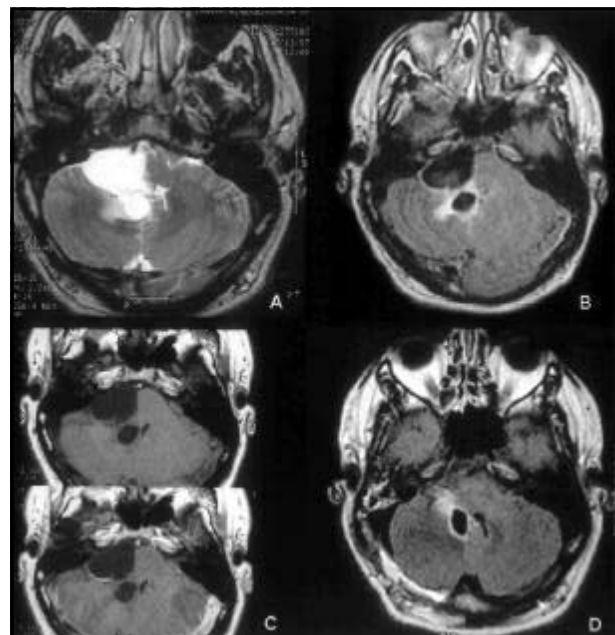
MRI Axial T2WI(A), Axial flair(B), Axial T1WI pre- and postcontrast (Gd-DTPA). Bulky cystic lesion in the right CPA cistern and small cyst in the right IV ventricle recess/ Axial Flair(D) after surgery: Removal of the cyst in the right CPA cistern and residual cyst within the IV Ventricle.
